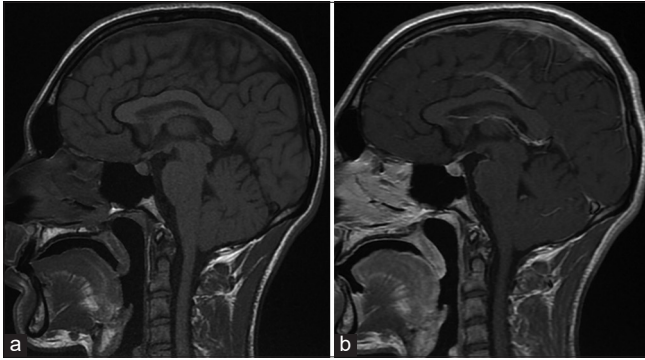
T1 sagittal section of hypothalamic-pituitary MRI before (a) and after (b) gadolinium injection showing the absence of the bright spot of the neurohypophysis (case 4).
